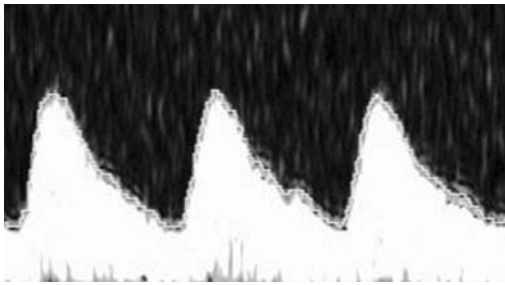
Absent end-diastolic flow in umbilical artery Doppler.
